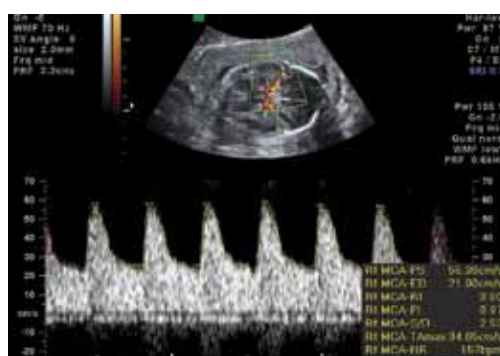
Centralised MCA doppler.
